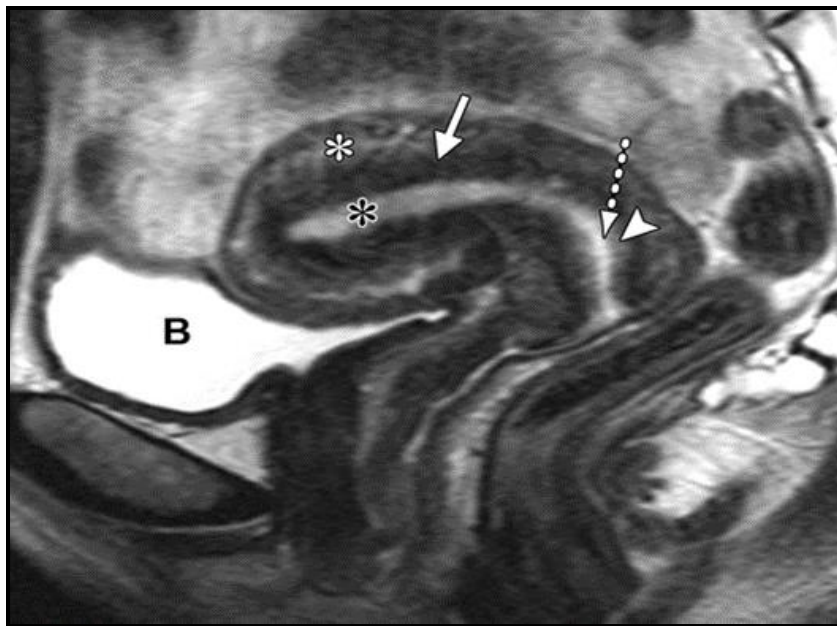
Midline sagittal T2-weighted MR image depicts the zonal anatomy of the uterus: endometrium (black*), junctional zone (solid arrow), and outer myometrium (white*). The striking difference in signal intensity between the junctional zone and the outer myometrium may reflect the higher density of smooth muscle cells in the junctional zone. In the cervix, a central cervical mucus (dotted arrow); endocervix (arrowhead); inner fibromuscular stromal layer, which is in contiguity with the junctional zone of the uterus and outer fibromuscular stromal layer, which is continuous with the outer myometrium. B = bladder Quoted from (*Yitta et al., 2011*).
